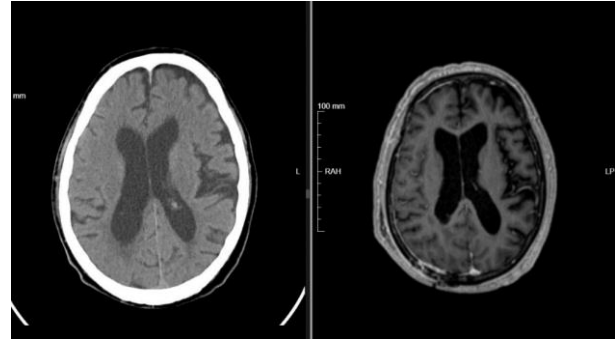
CT scan and MRI 1 year after surgical treatment plus radiotherapy.
